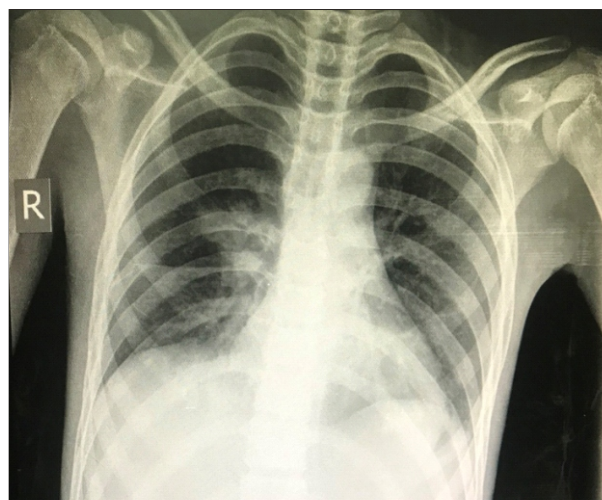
Chest x-ray after treatment showing resolution of the cavity
